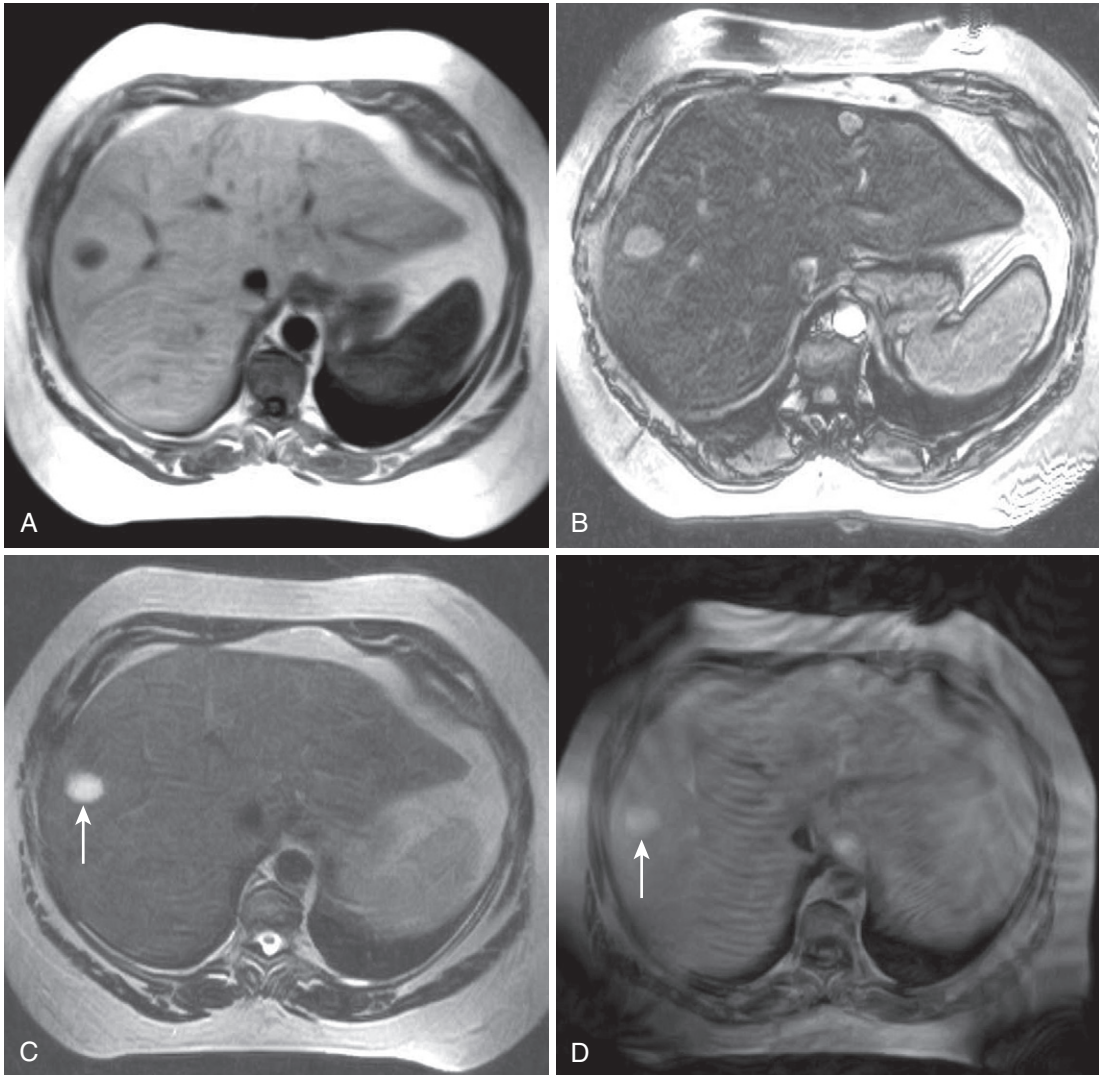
Liver magnetic resonance imaging (MRI) obtained on a 0.3-Tesla system. Axial in-phase (A) and out-of-phase (B) images display relatively markedly diminished signal throughout the liver on the out-of-phase image compared with the in-phase image, indicating fatty infiltration. The axial T2-weighted image (C) reveals a small hyperintense lesion (*arrow* in C and D), which enhances as seen on the delayed T1-weighted gradient echo image (D), degraded by low signal-to-noise ratio and breathing motion artifact.
